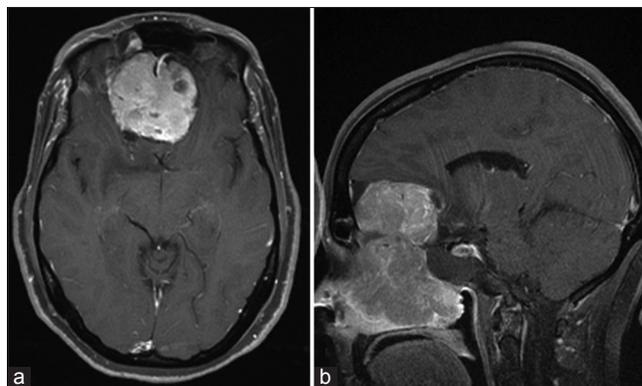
Axial (a) and sagittal (b) T1-weighted magnetic resonance imaging showing a contrast-enhancing sinonasal mass with intracranial extension through the cribriform plate into the anterior cranial fossa, maxillary, and sphenoid sinuses
